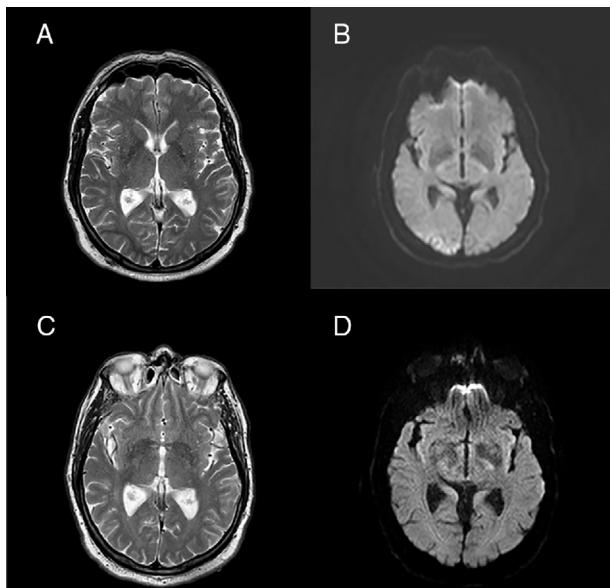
Brain MRI study. (A) T2-weighted sequence showing hyperintensity in the right visual cortex and adjacent subcortical hypointensity. (B) Diffusion-weighted sequence showing an area of restricted diffusion in the right visual cortex. (C and D) T2- and diffusion-weighted sequences obtained after onset of insulin therapy, showing total resolution of the alterations.
